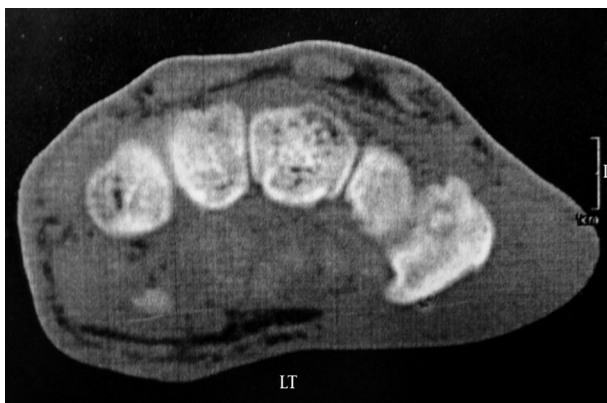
Computed Tomographic Scan, Axial View of the Left Wrist Showing a Nidus in the Trapezium.
